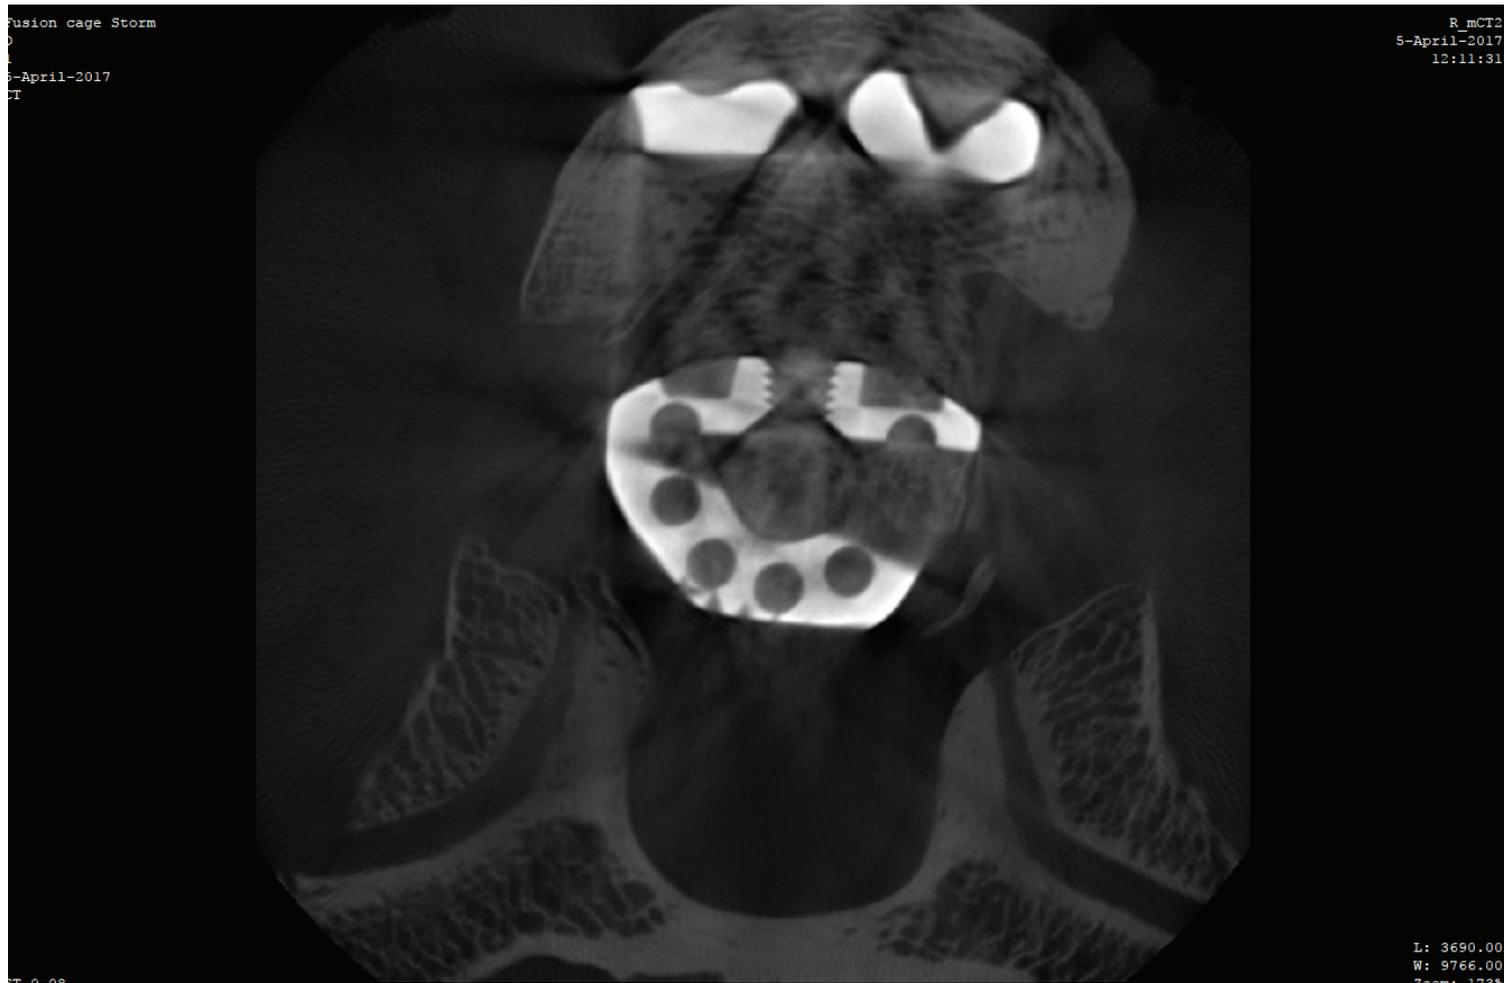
Same patient as figure 1. On micro CT, performed 22 months postoperatively, bone ingrowth is seen in more detail through the Syncage®.
